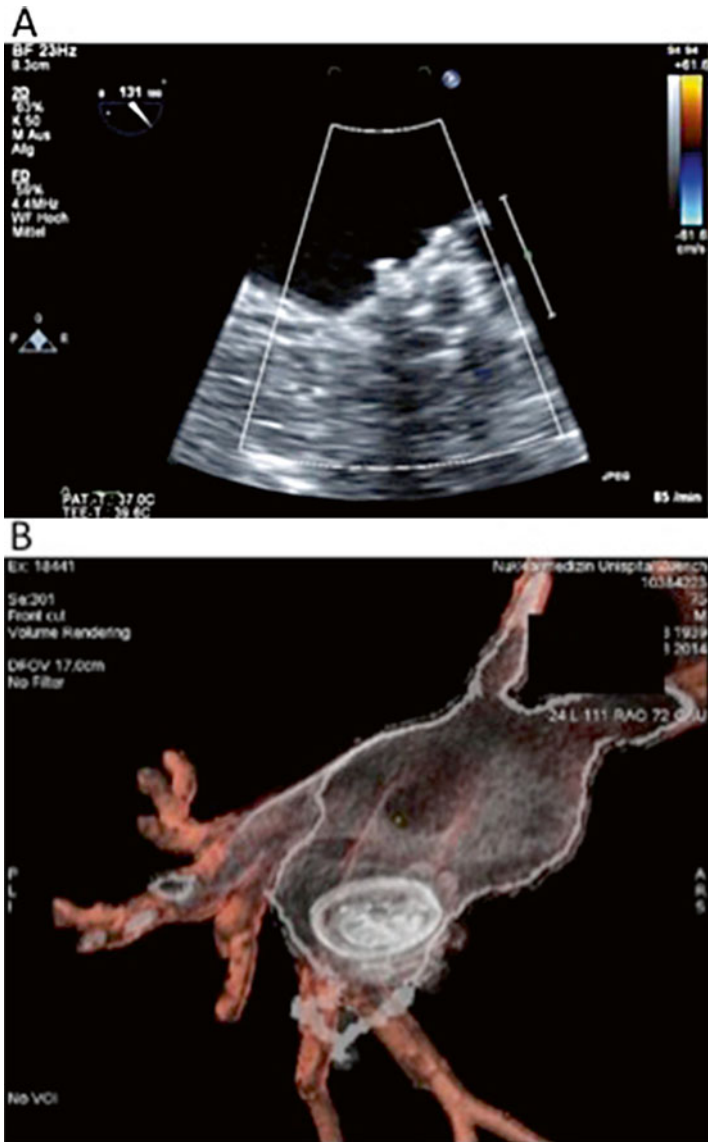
(A) Follow-up TEE at 3 months after Implantation of an Amplatzer Cardiac Plug showing no thrombus formation. (B) Follow-up CT showing no device thrombus
